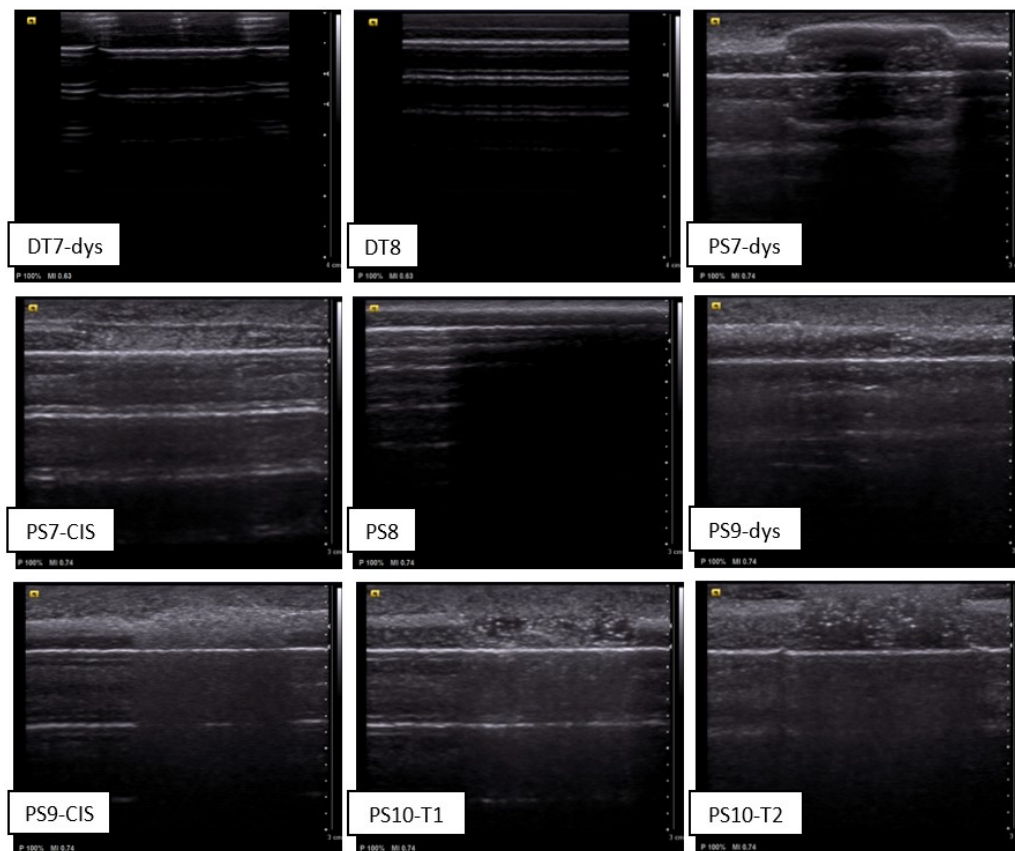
For every tumour type in the tumour test pieces an ultrasound scan has been selected. The labels correspond with the names of the tumour test pieces addressed in table 3 and the tumour type that is scanned in this tumour test piece, where dys is an abbreviation for dysplasia. The bright (white) line around 4 or 8 mm in depth represents the bottom surface of the tumour test piece. Everything above this line represents the cross-section of the tumour test piece. Tumour test piece DT7 is two-layered and contains the dysplasia tumour type. Tumour test piece DT8 is two-layered and does not contain a tumour type. Tumour test piece PS7 is three-layered and contains the dysplasia and CIS tumour type. Tumour test piece PS8 is two-layered and does not contain a tumour type. Tumour test piece PS9 is three-layered and contains the dysplasia and CIS tumour type. Tumour test piece PS10 is three-layered and contains the T1 and T2 tumour type.
